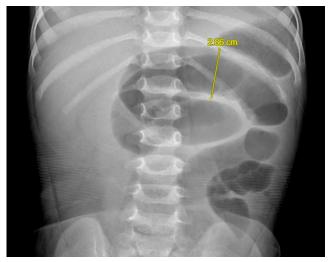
Plain abdominal radiograph shows intestinal dilatation (yellow line) with an estimated diameter of 2.86 cm caused by obstruction.
